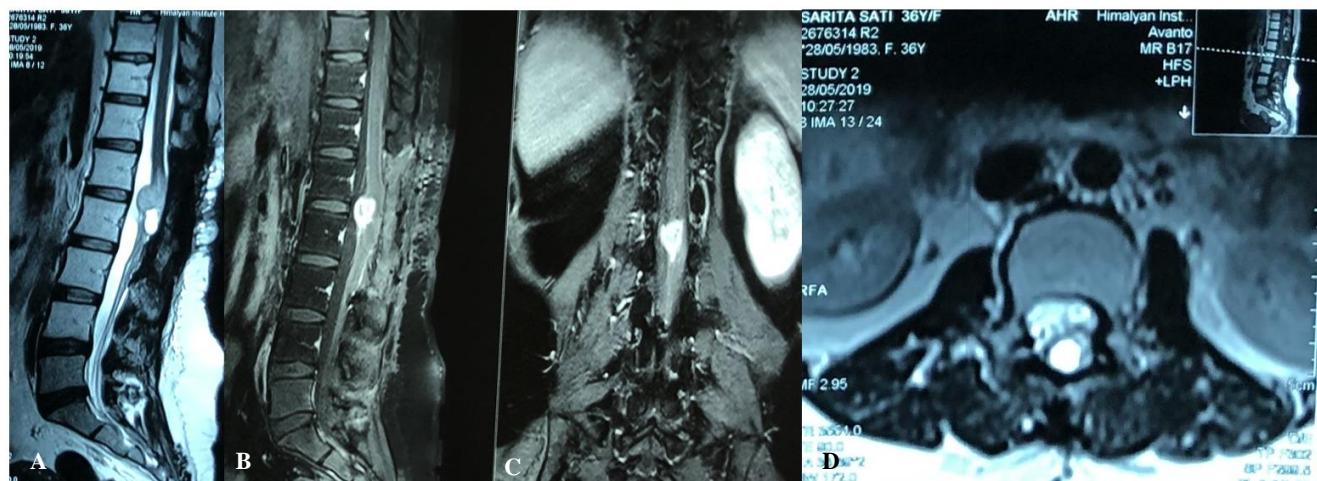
(A-D): MRI images at presentation.
